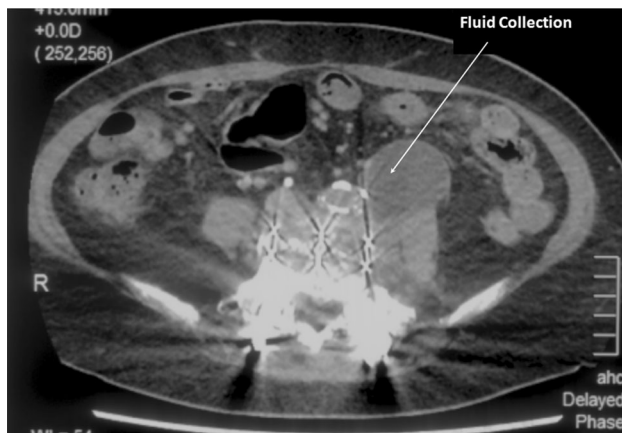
MRI scan of the abdomen showed a retroperitoneal fluid collection measuring 6 by 5 cm causing obstruction of the left ureter leading to the left hydronephrosis and hydronephrosis
